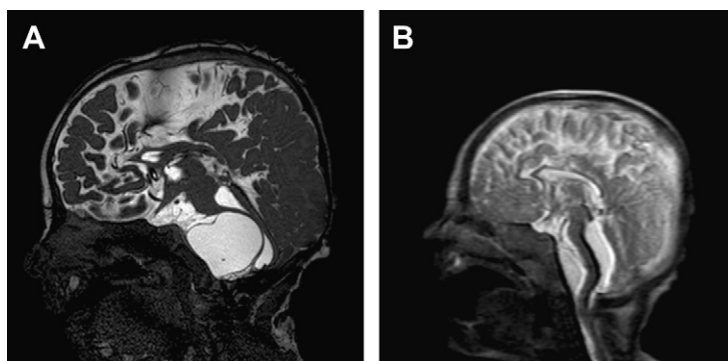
Case example: large prepontine arachnoid cyst. A 26-week preterm female infant with grade 4 intraventricular hemorrhage developed post-hemorrhagic hydrocephalus and underwent shunt placement at age 4 weeks. She presented at age 7 months with pneumonia, respiratory distress, apnea, and poor feeding. MRI showed a large cyst anterior to the brainstem with severe thinning of her pons and medulla (A). She underwent endoscopic membrane fenestration through existing shunt tract, with improvement of symptoms within 24 hours. MRI scan 48 hours later (B) showed significant improvement of brainstem compression.
